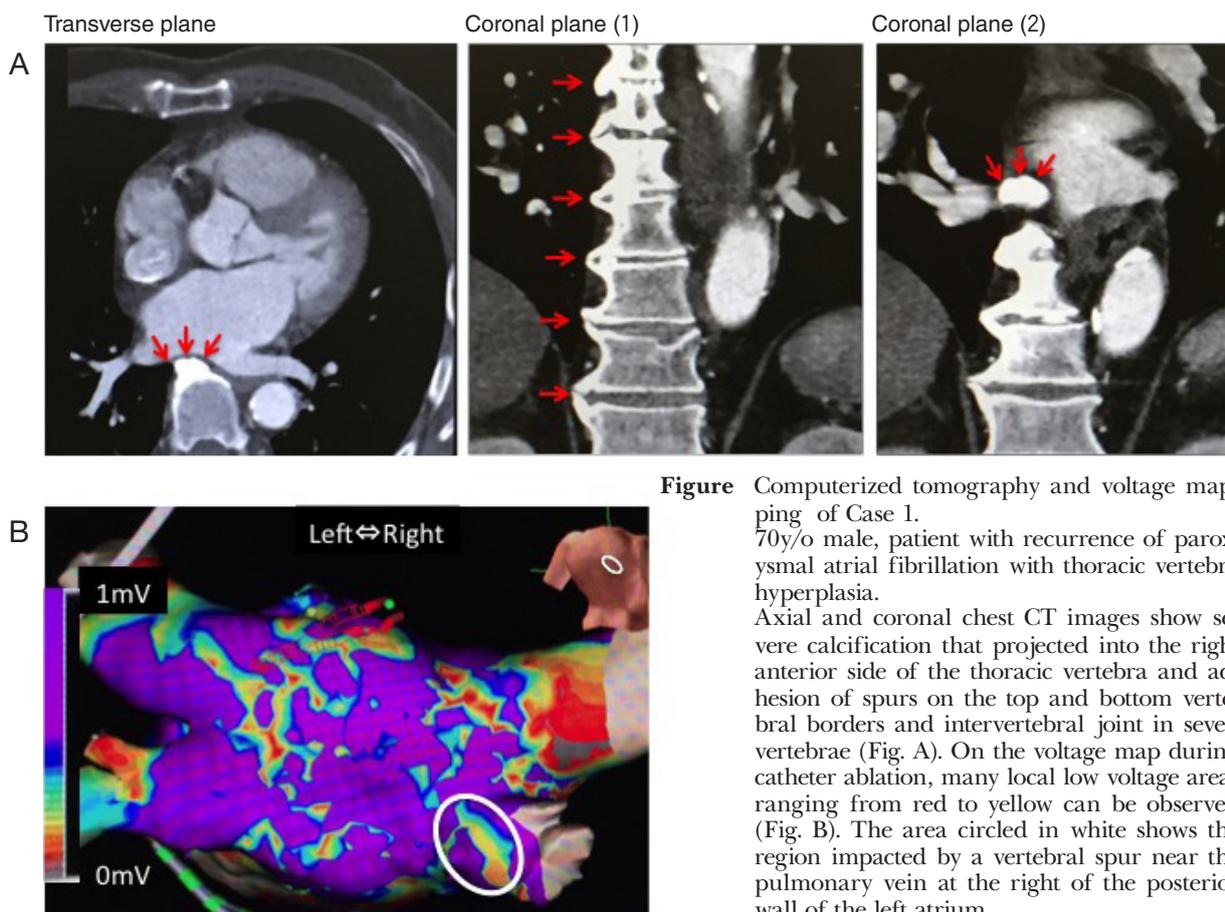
Figure Computerized tomography and voltage mapping of Case 1. 70y/o male, patient with recurrence of paroxysmal atrial fibrillation with thoracic vertebra hyperplasia. Axial and coronal chest CT images show severe calcification that projected into the right anterior side of the thoracic vertebra and adhesion of spurs on the top and bottom vertebral borders and intervertebral joint in seven vertebrae (Fig. A). On the voltage map during catheter ablation, many local low voltage areas ranging from red to yellow can be observed (Fig. B). The area circled in white shows the region impacted by a vertebral spur near the pulmonary vein at the right of the posterior wall of the left atrium.
